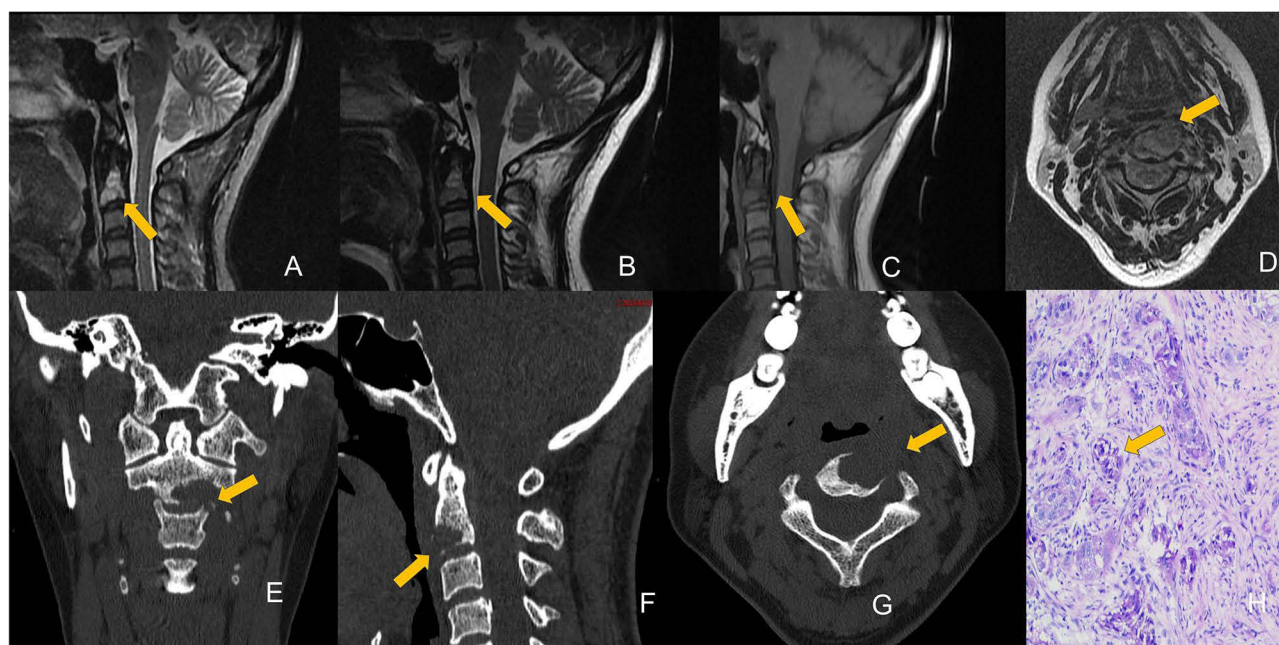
Squamous Cell Carcinoma Metastasis to the C2 Vertebral Body, Female, 45 years old, with neck pain and limited mobility for about 4 months. (A) Fat-suppressed T2WI sagittal view shows the axis vertebra with intermediate and slightly high signal intensity. (B and D) T2WI sagittal and axial views show the lesion with intermediate and slightly high signal intensity. (C) T1WI sagittal view shows the lesion with intermediate signal intensity. (E–G) CT scan without contrast shows the lesion with mild expansile, lytic bone destruction, no clear boundary. (H) HE (×20) shows that tumor tissue is observed to grow invasively within dense fibrous tissue. The tumor cells are arranged in clusters and nests (arrow), exhibiting large and hyperchromatic nuclei, eosinophilic cytoplasm, and visible nucleoli.
